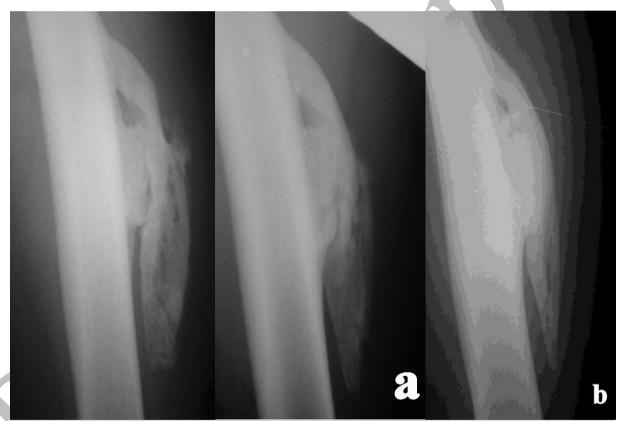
Lateral radiograph four months after the initial injury.
